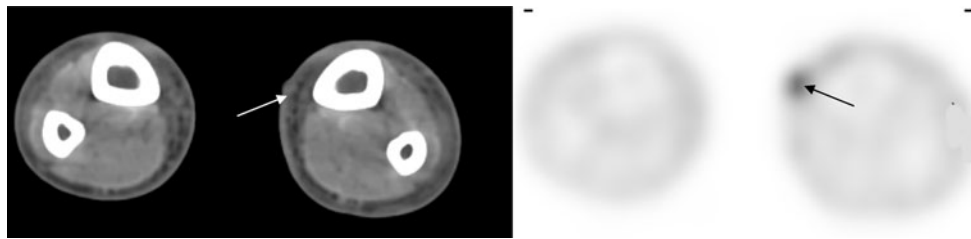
Skin KS in a 45-year-old man with AIDS. Transaxial images of FDG PET-CT demonstrate a skin lesion with moderate uptake (SUV 3.8) in the left medial thigh (*arrows*). Skin lesion of KS is
